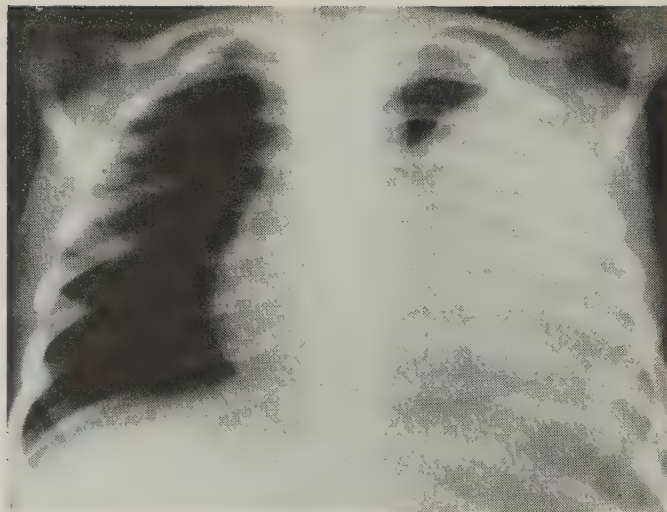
This is a radiograph of the chest of J. H. prior to tetracycline-oleandomycin therapy.
